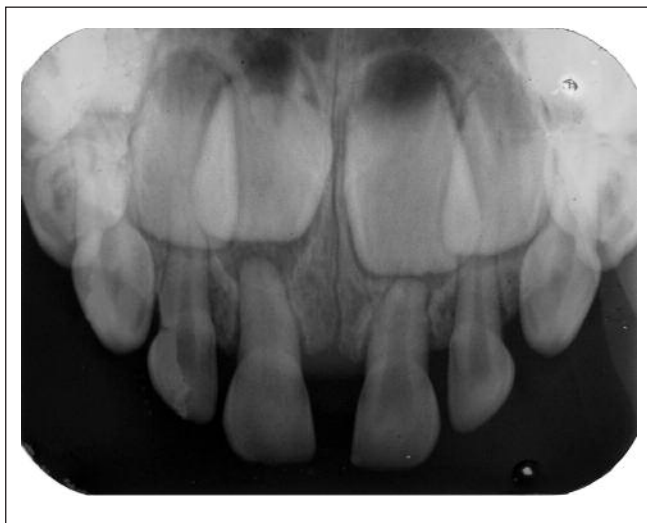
A marked obliteration of the pulp space is observed when compared to the initial radiograph 3 months after intrusion. The intruded tooth has also re-erupted.
